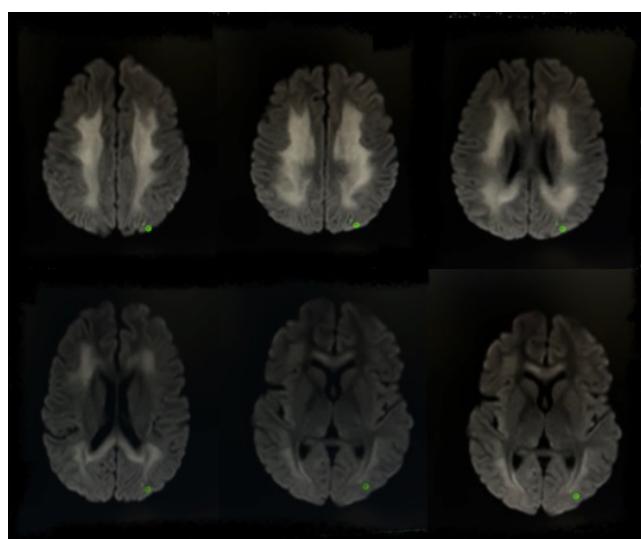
Diffusion MRI, which showed significant diffusion restriction in the periventricular area
